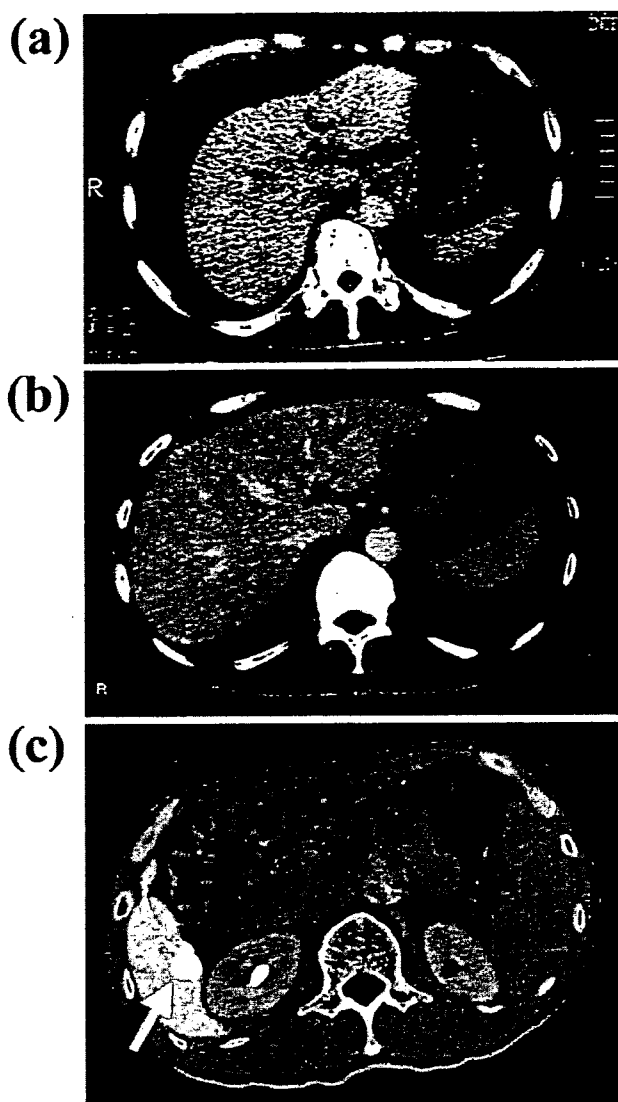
(a) Dynamic CT before adefovir therapy shows liver cirrhosis with massive ascites. (b) Dynamic CT after 10 months of adefovir therapy shows that the liver volume had increased and that the ascites had disappeared. (c) CT during hepatic arteriography in the first phase showed a hyperdense lesion in segment 6 (white arrow).
